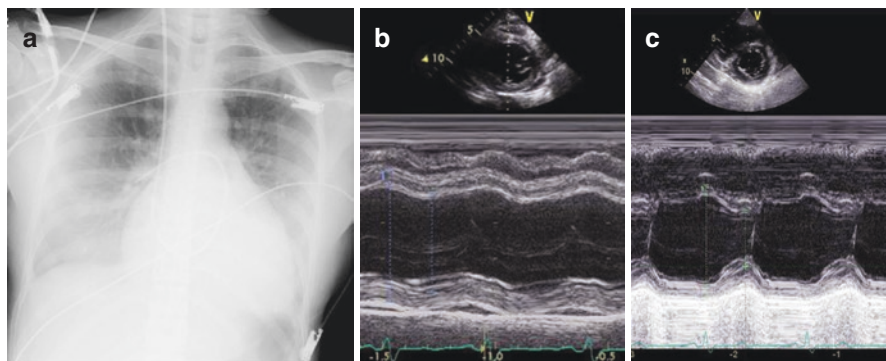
A case with HDP. Chest radiography at the time of diagnosis (a): the cardiothoracic ratio was 66%, and pulmonary congestion was observed. Left parasternal-LV short axis M-mode echocardiography at the time of diagnosis (b), showing mild dilatation and marked reduction of systolic function of the left ventricle, and after 6 months (c), showing that LV systolic function had improved to the normal range. *HDP* hypertensive disorders in pregnancy, *LV* left ventricle
